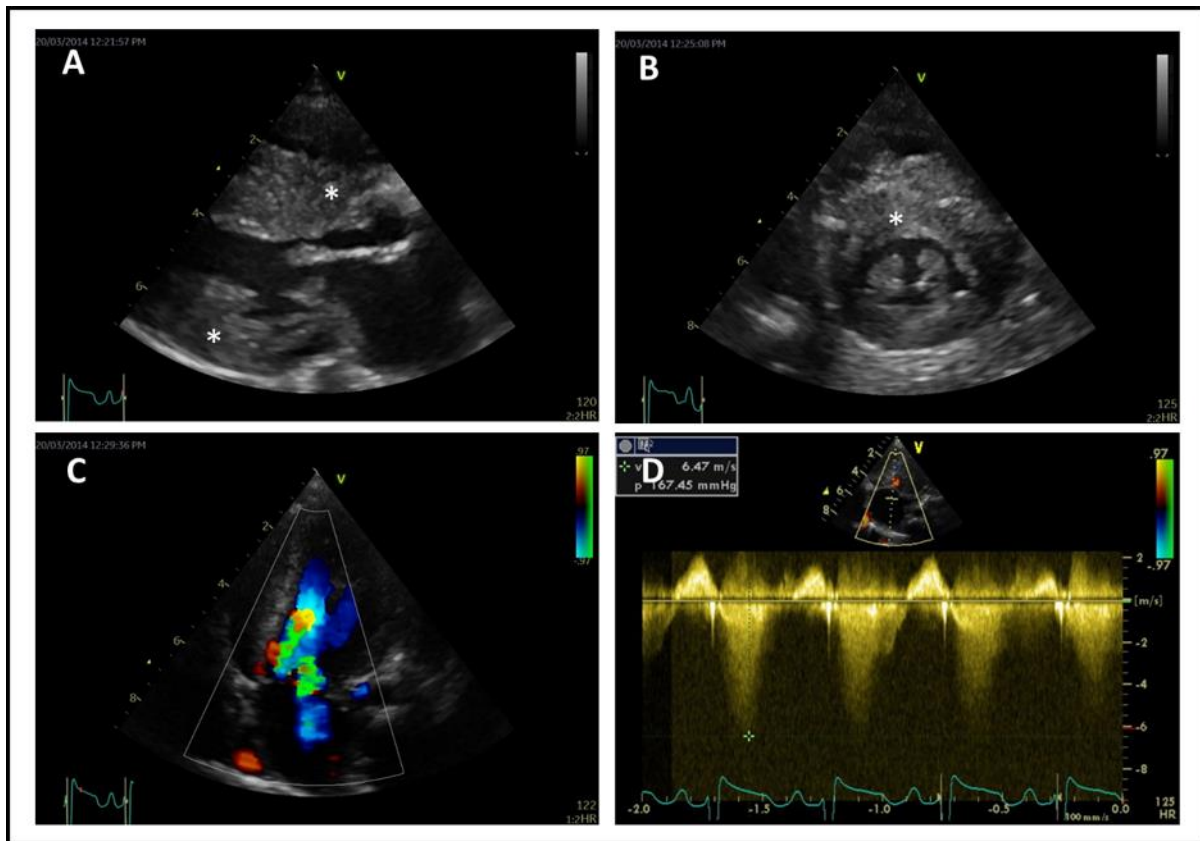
Echocardiographic images of patient 3, Related to Figure 1. Transthoracic echocardiographic imaging of patient 3 (Noonan syndrome, *RAF1*, male, 11 months of age) at the time of admission to the hospital for surgical left ventricular outflow tract resection. Depicted are the parasternal long axis view (panel A), parasternal short axis view (panel B), and the apical 5-chamber view (panel C and D) with color Doppler (panel C) and continuous wave (CW) Doppler (panel D) imaging. There is severe myocardial thickening (*), the peak gradient over the left ventricular outflow tract measures 130 mmHg.
